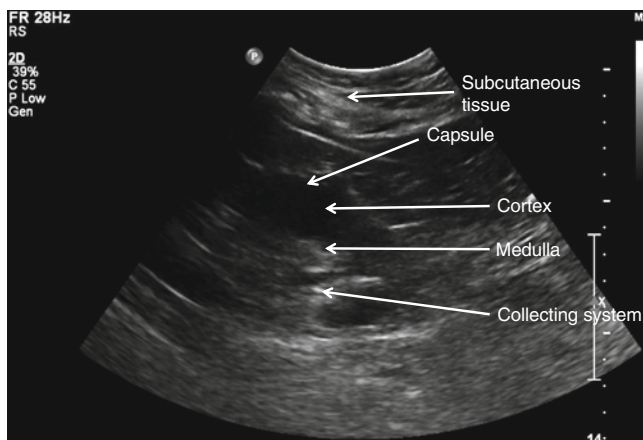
Prone ultrasound, same patient
